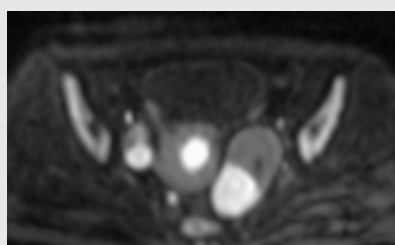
Diffusion-weighted images – DWI ($b = 1000$)
